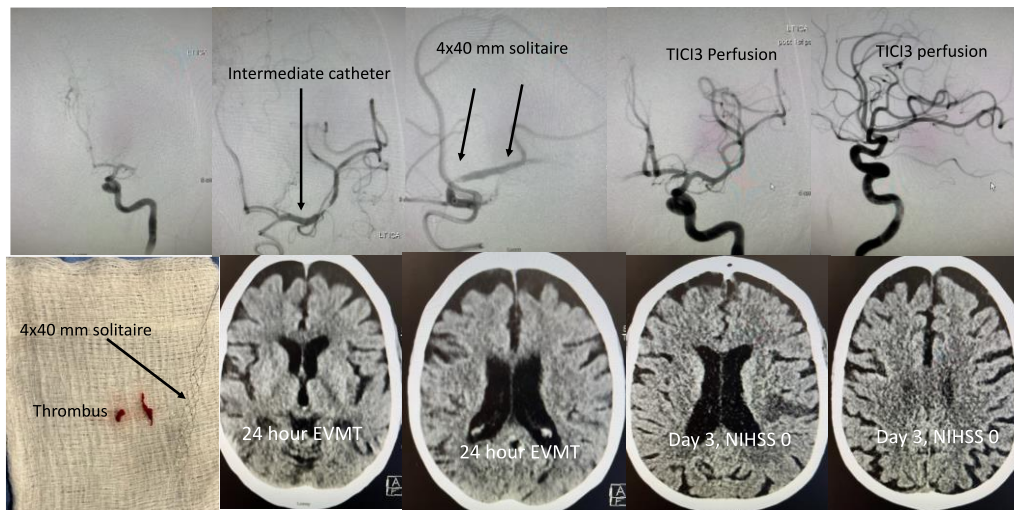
50 year-old-woman admitted with left MCA non LVO stroke beyond thrombolytic window. NIHSS improved from 9 to 3 on day 3. On day 4, patient was found to have right gaze, left hemiparesis and right neglect (GWNS stroke scale 3), NIHSS 19, ASPECT9 and CTA demonstrated right MCA distal branch occlusion. Patient underwent EVMT with TIC13 and her NIHSS went to 3 in 24 hours and 1 on day 5 despite density on the CT head.
